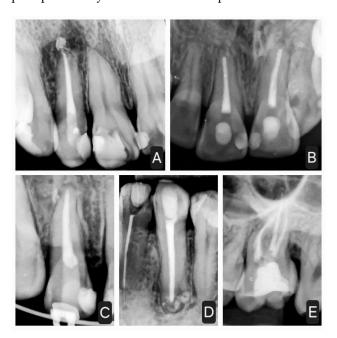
Control periapical X-rays of the five cases treated with conventional non-surgical endodontics supplemented with aPDT and PBMT: (A) Case 1, Tooth 1.2. An apical puff can be observed. (B) Case 2, Teeth 1.1 and 2.1. The root canals appear fully obturated. (C) Case 3, Tooth 1.2. A straight root canal is completely sealed. (D) Case 4, Tooth 3.3. The tooth is obturated in the cervical, middle, and apical thirds. (E) Case 5, Tooth 2.7. Endodontic obturation of the mesiobuccal, distobuccal, and palatal canals is visible. In all cases, bone tissue regeneration can be observed at the apical level.
